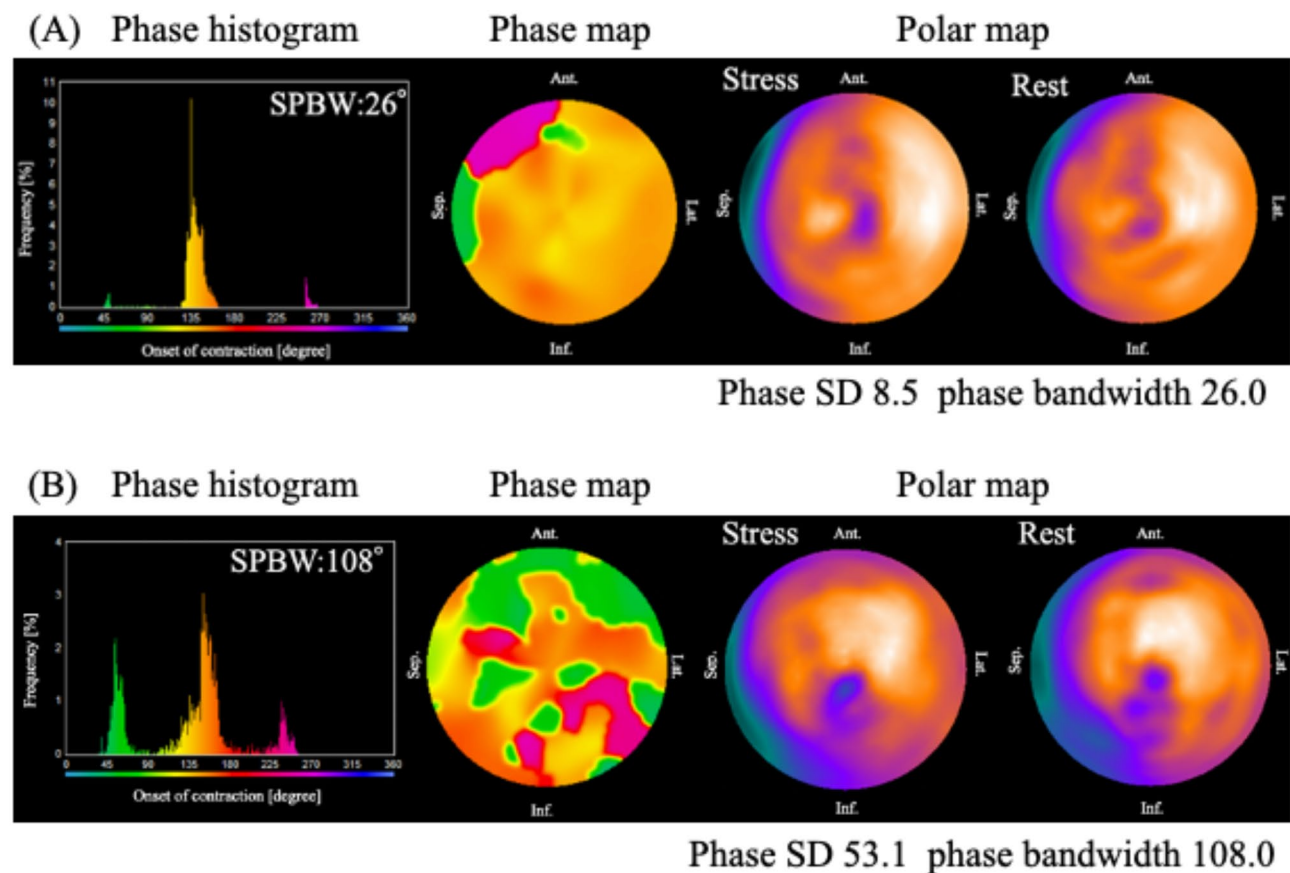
Representative stress phase histograms, phase map, and polar map images of a patient without LV mechanical dyssynchrony (A) and a patient with severe LV mechanical dyssynchrony (B). Patient A had improved LVEF on echocardiography after 6 months of HF treatment. Patient B had not improved LVEF on echocardiography after 6 months of HF treatment
